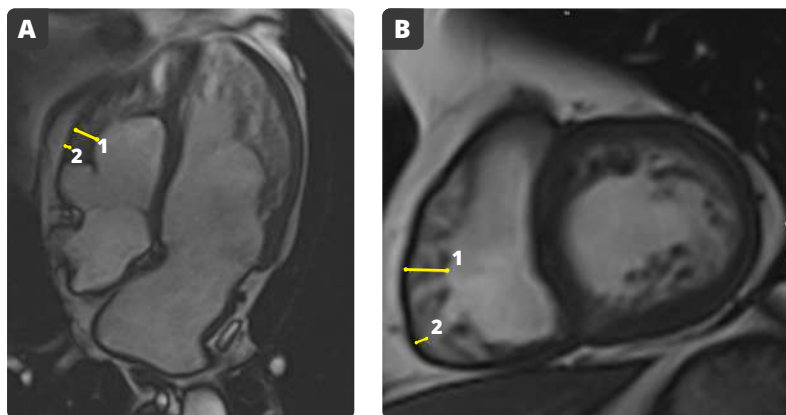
Valoración del grado de hipertrabeculación del ventrículo derecho por resonancia magnética cardiovascular en un A) plano apical 4 cámaras y B) eje corto
